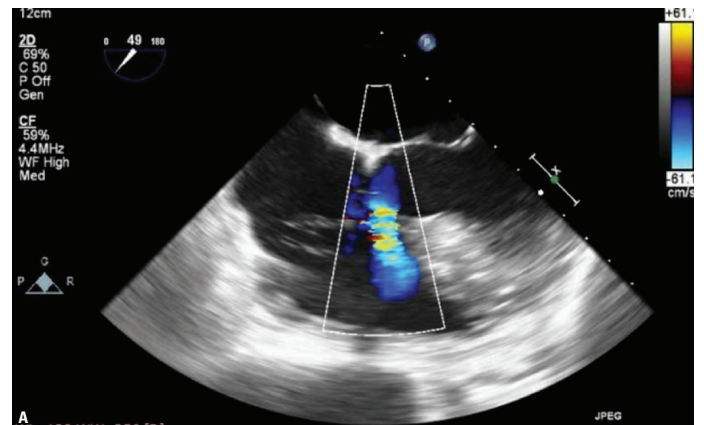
(A) Transesophageal echocardiographic view of ventricular septal defect. (B) Left ventriculography in left anterior projection. Arrow indicated septal defect.
